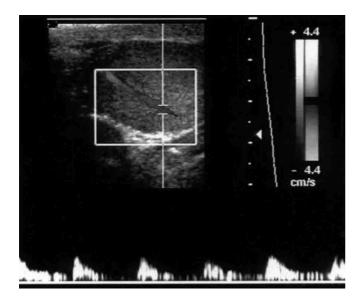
Transmedial artery with Doppler flow. This can sometimes be mistaken for a testicular fracture. Adapted from Figure 3, Dogra VS, Rubens DJ, Gottlieb RH, Bhatt S. Torsion and beyond: new twists in spectral Doppler evaluation of the scrotum. *J Ultrasound Med.* 2004;23(8):1077–1085.
